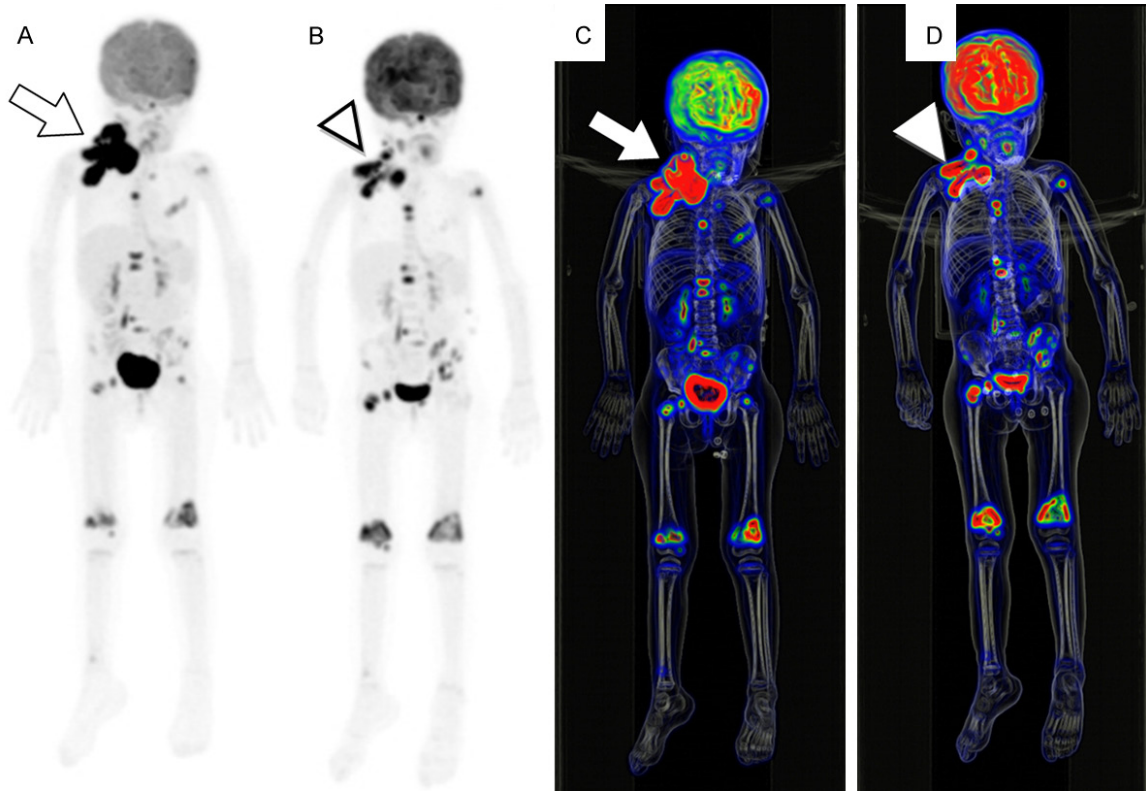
Therapy monitoring in 3-year-old girl with bone and laterocervical lymph nodes metastatic neuroblastoma. FDG PET maximum intensity projection image (A) and Volume Rendering (C) show high FDG uptake (arrows); partial response is observed after systemic chemotherapy (B and D-arrowheads).
